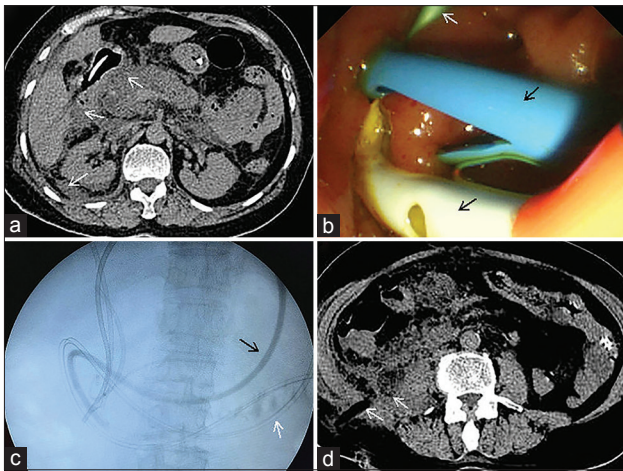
(a) CT scan revealed retroperitoneal air and fluid collection (white arrows); (b) two biliary stents (black arrows) and one pancreatic stent (white arrow) were placed during salvage ERCP; (c) nasoduodenal decompression tube (black arrow) and a nasojejunal feeding tube (white arrow); (d) CT-guided percutaneous drainage of the retroperitoneal fluid collection (white arrows). CT: Computer tomography; ERCP: Endoscopic retrograde cholangiopancreatography.
